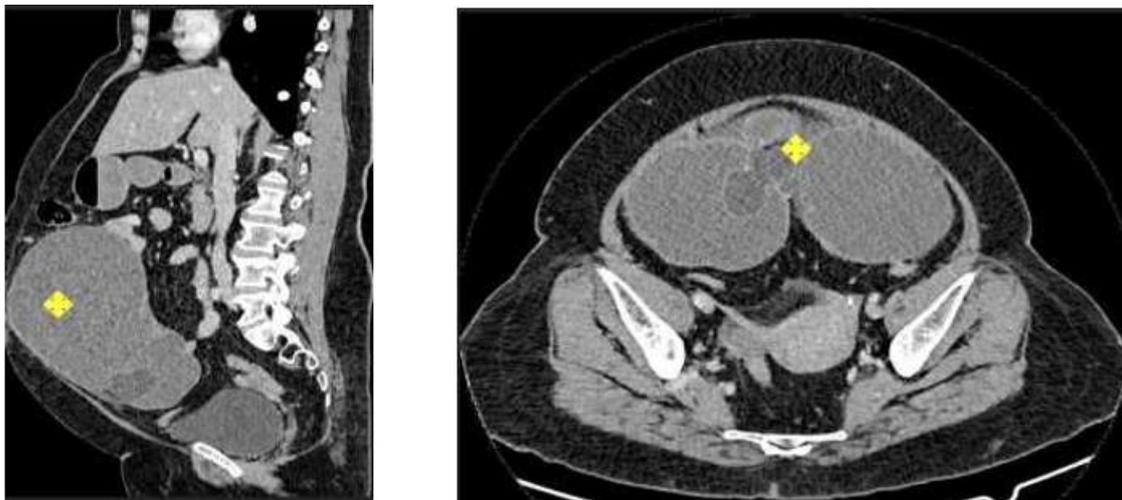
CT scan Whole abdomen
